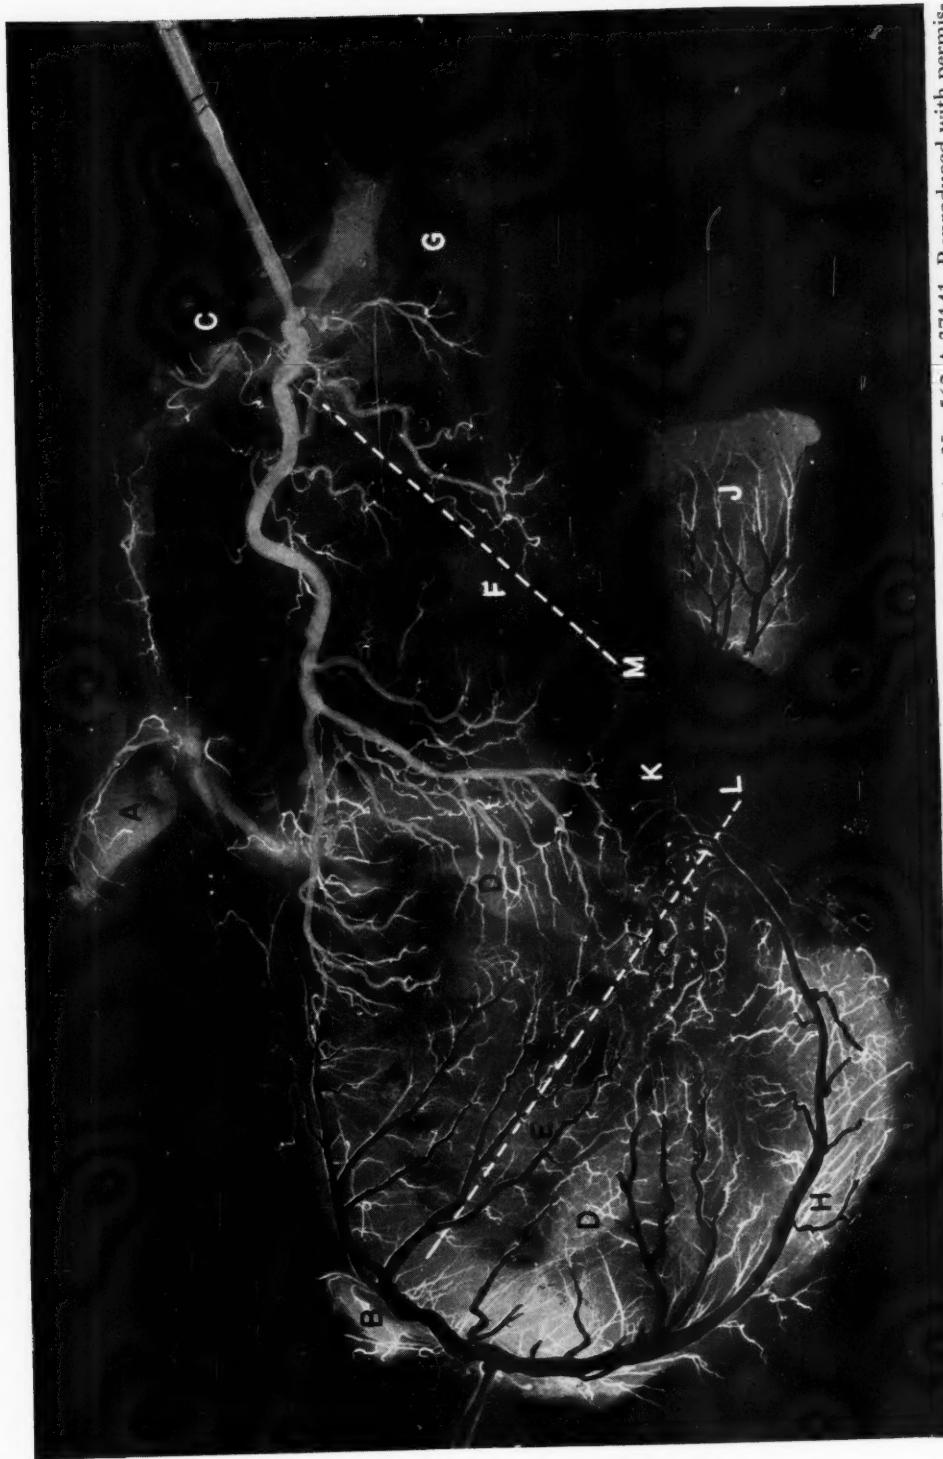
Colored photograph of roentgenogram of heart with normal coronary arteries. Series No. 562 A 37141. Reproduced with permission of the publishers, The C. V. Mosby Company, from the *Am. Heart J.*, 15: 551, 1938.¹
